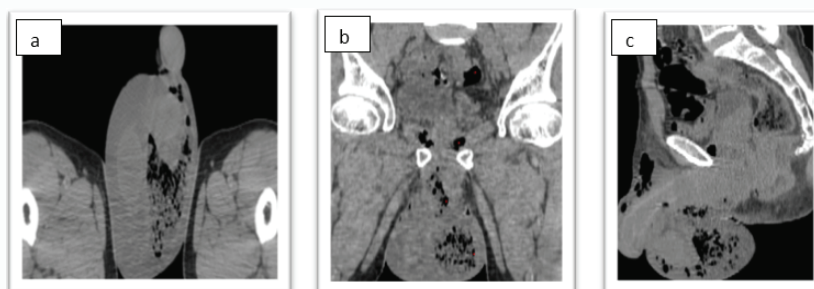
Axial, coronal and sagittal pelvic CT images without injection of iodinated contrast product, revealing intra scrotal, perineal and abdomino-pelvic hydro-aeric levels in favor of Fournier's gangrene.
